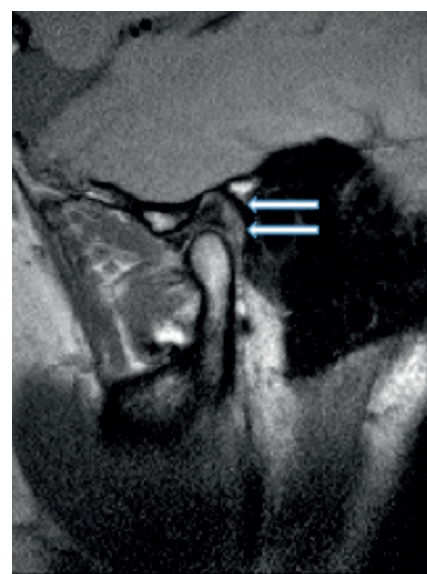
Proton-density-weighted MR image, open mouth view of left TMJ demonstrating proliferation of cartilage in the retrodiscal area, between condyle and glenoid fossa (patient 2).
